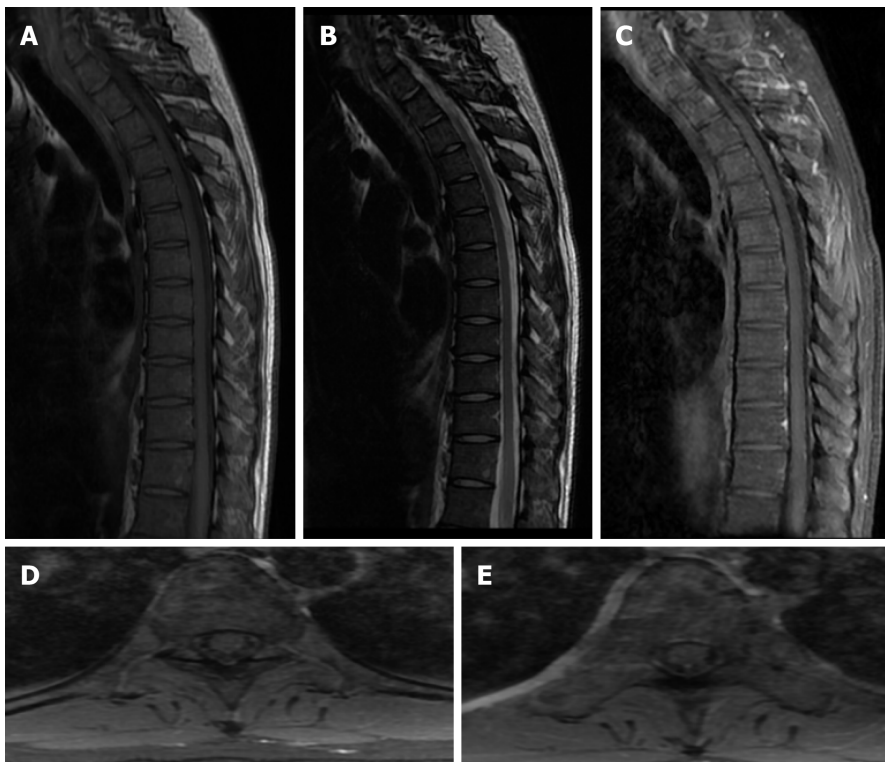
Abnormal hyperintensities on spinal magnetic resonance imaging also resolved at three-month follow-up.
